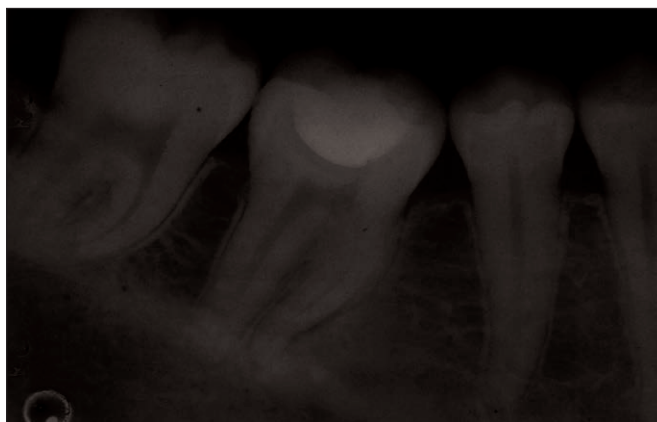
Periapical radiograph at the 45-day recall.
